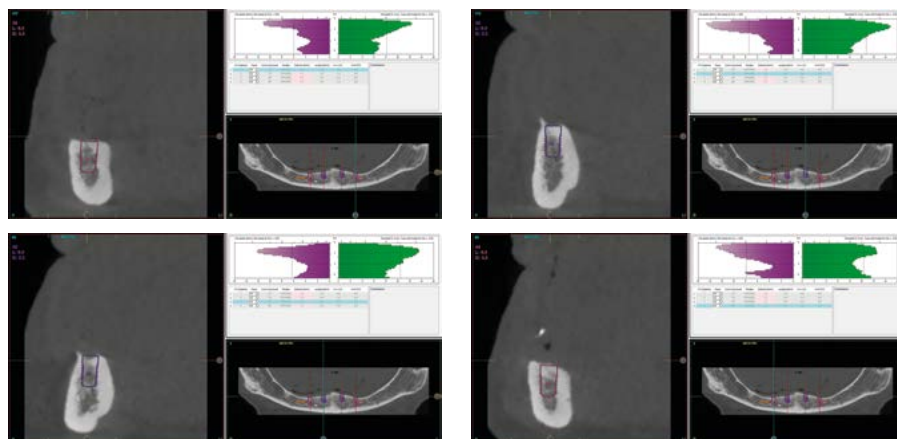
CBCT planning sections showing the planned placement of four 6.5mm reduced-diameter implants in the mandible. The combination of high bone density and advanced resorption may enhance peri-implant vascularisation while preserving remaining bone for potential future retreatment
